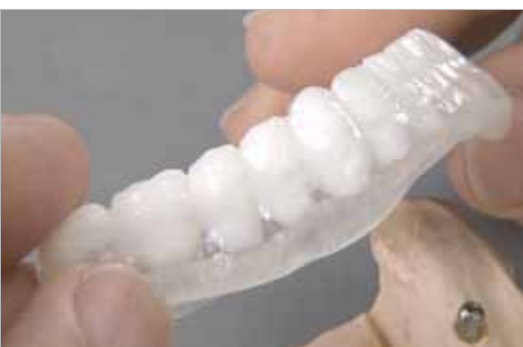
The planning template for the CT or DVT image is prepared from barium sulphate-containing plastic teeth with anatomical crown emergence profile.
